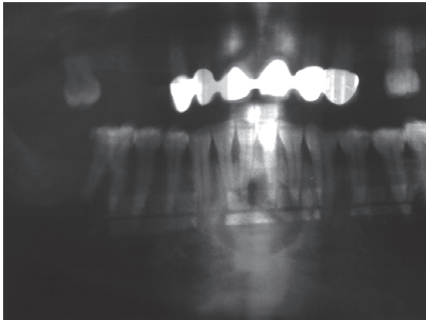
Orthopantomogram revealed generalized horizontal bone resorption
